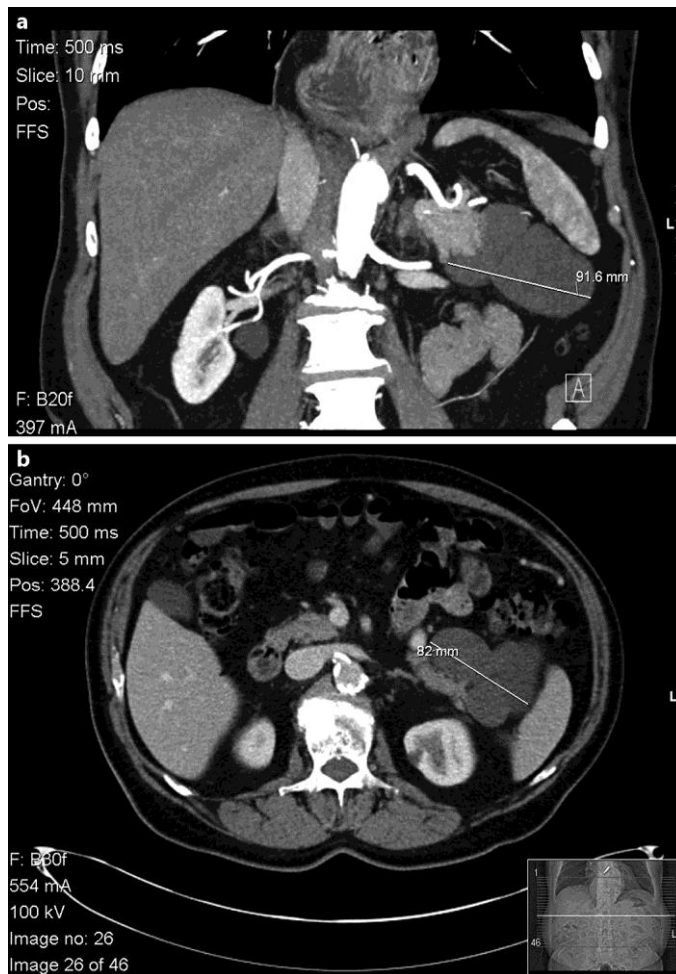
Coronal (a) and sagittal (b) CT images showing a loculated cystic lesion in the tail of the pancreas closely involving the spleen.
